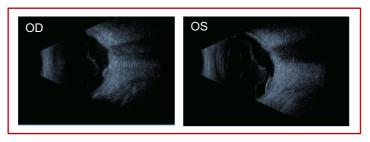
B-scan ultrasonography of both eyes.
